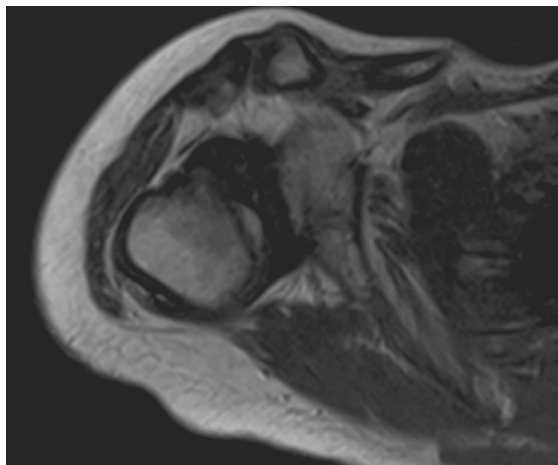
MRI image from a patient with a dislocation.
